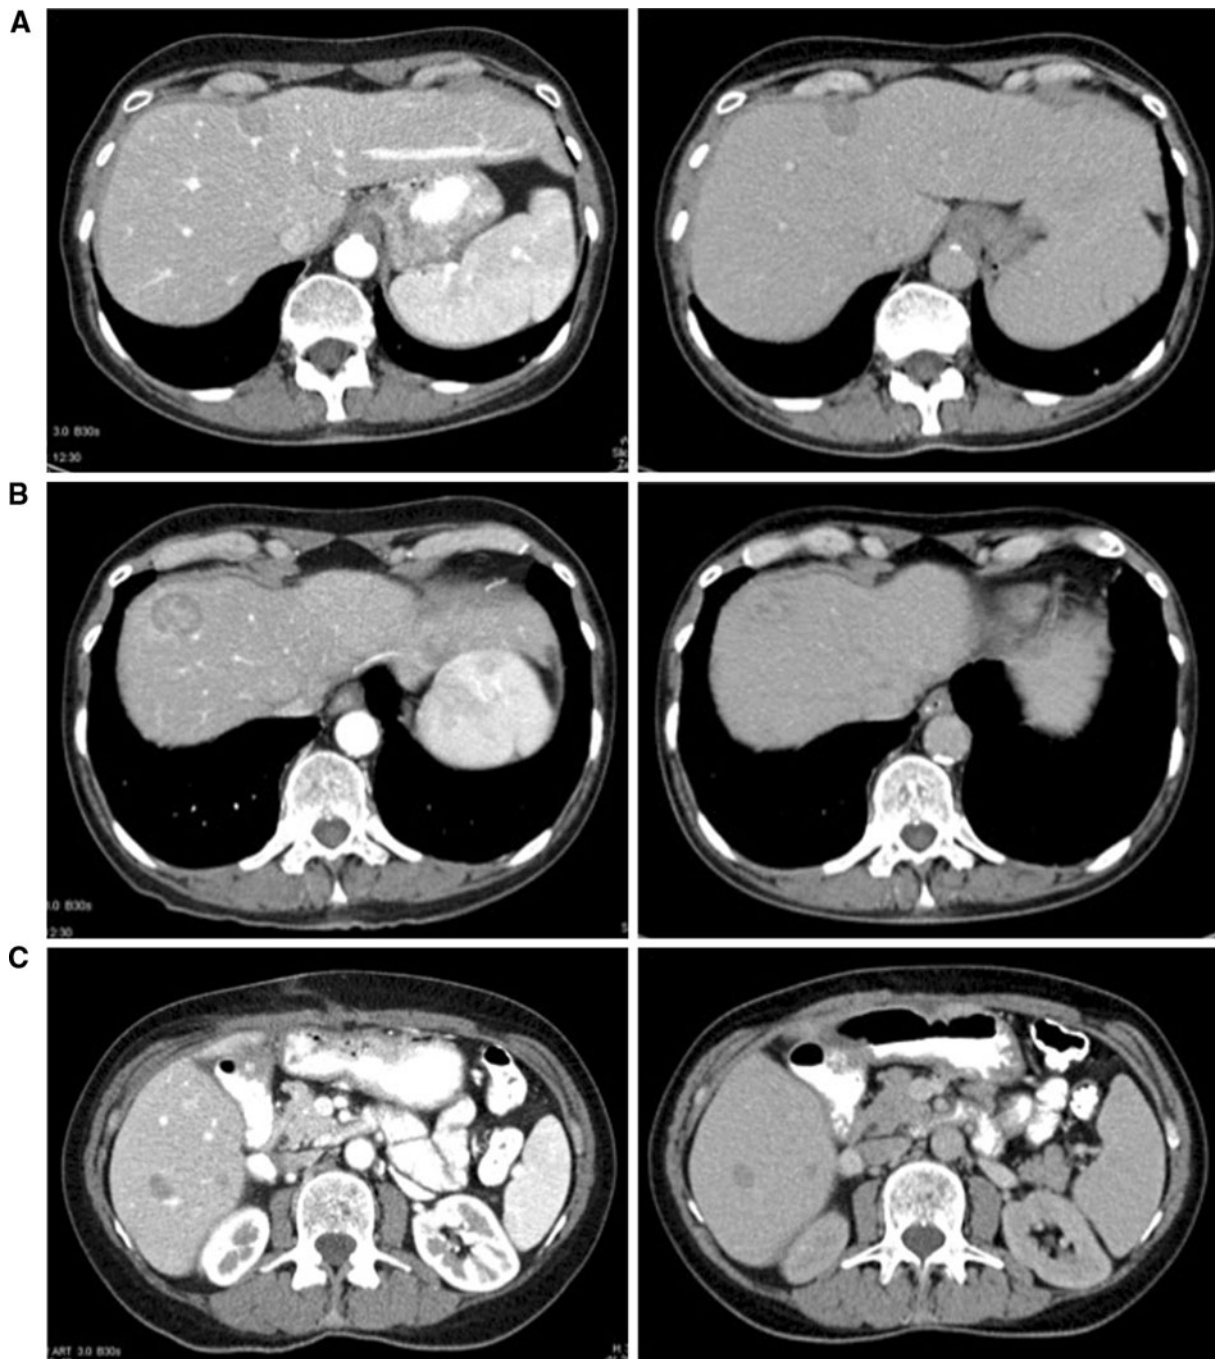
CT scans reveal target lesions followed for treatment-related response to chemosaturation with percutaneous hepatic perfusion (CS-PHP) in the case patient with metastatic sarcoma isolated to the liver. The CT scans on the *left* were taken on January 25, 2010, before
